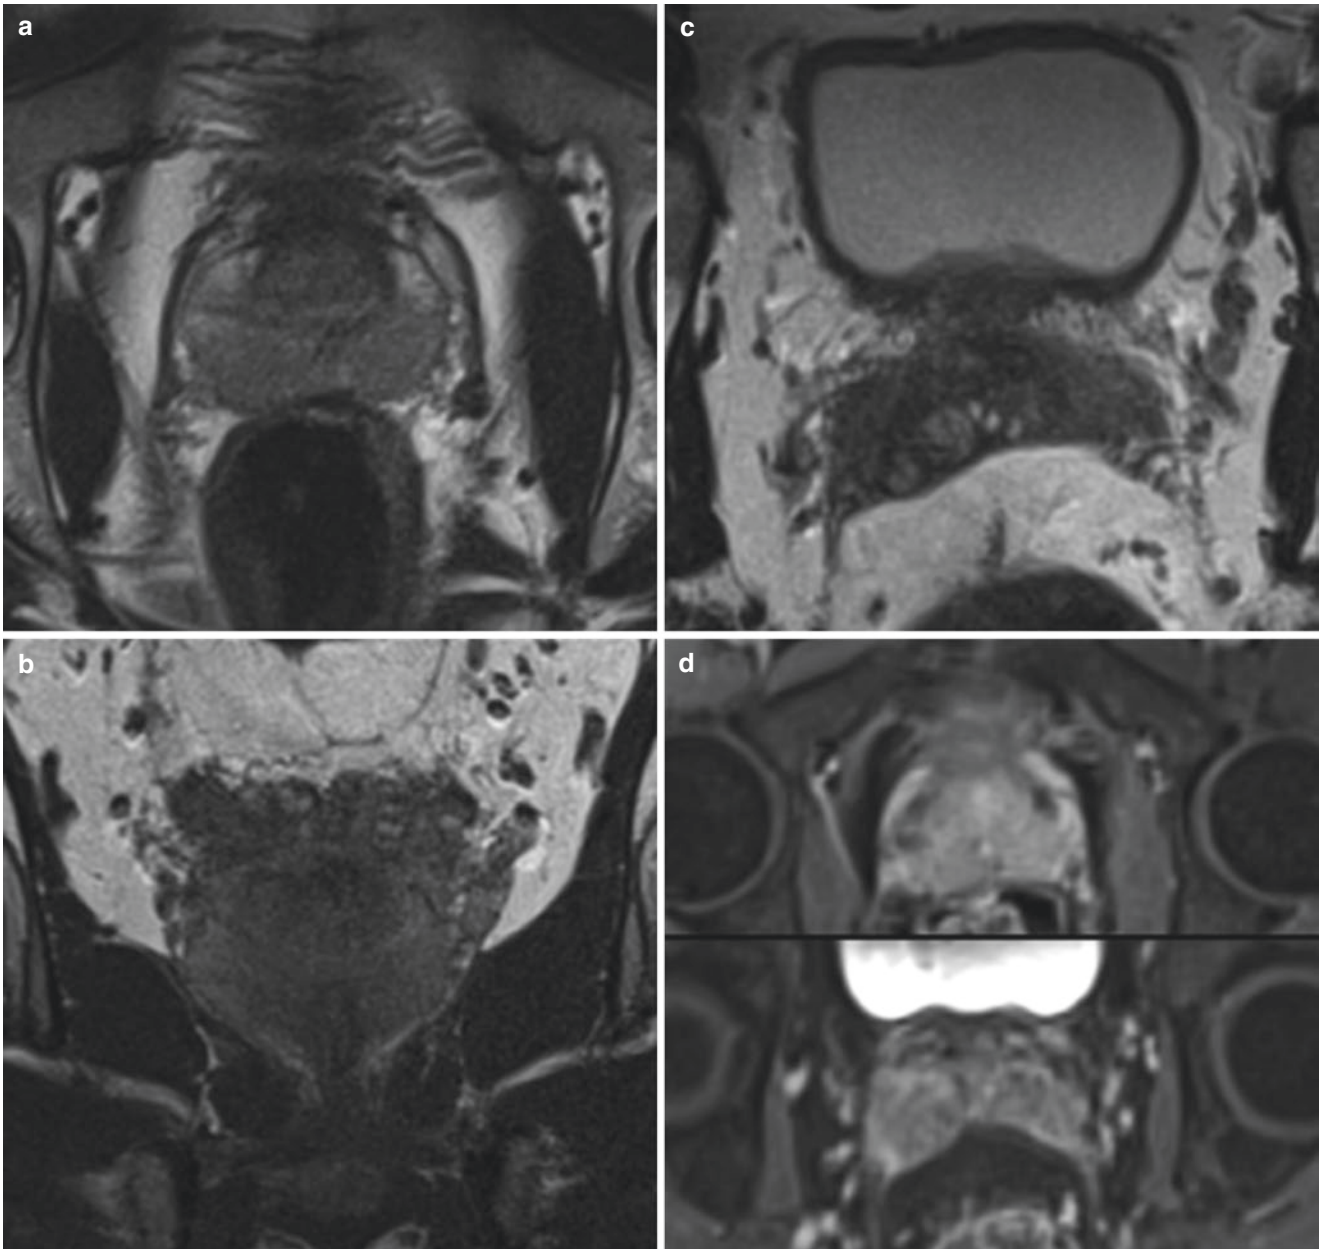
Prostatitis in a 30-year-old man with prostate-specific antigen level of 5.0. Axial (a,c), coronal (b) T2-weighted MR image shows diffuse low-signal intensity in entire peripheral zone and SV due to
